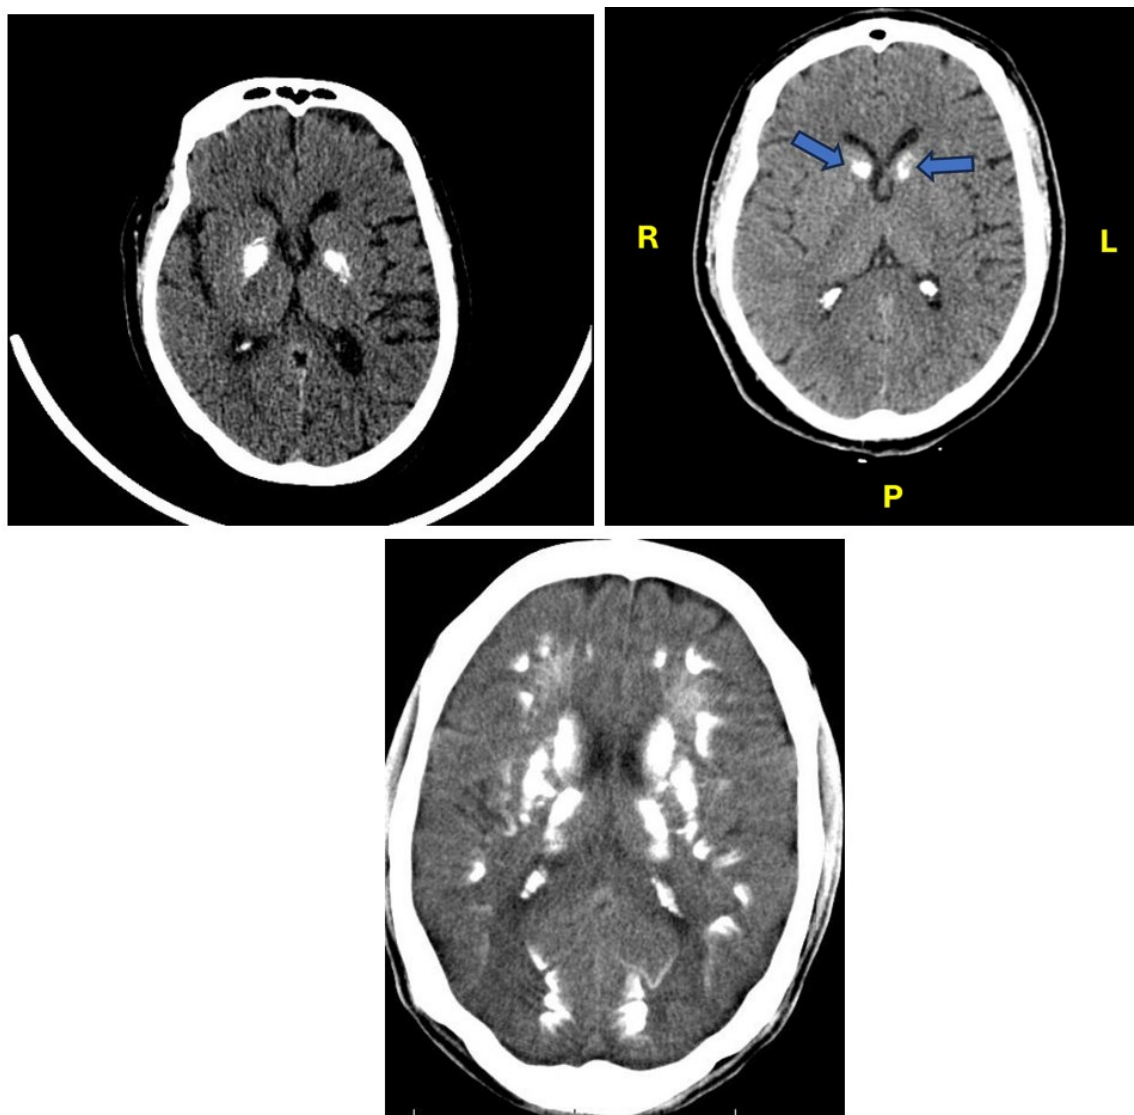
Brain CT scan showing bilateral calcifications involving the caudate and lenticular nuclei consistent with Fahr syndrome
